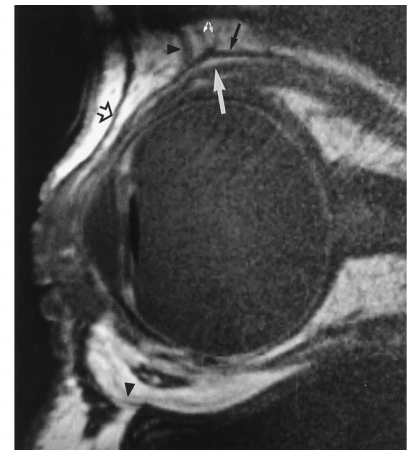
T1-weighted sagittal MR image (600/20/2) of the left orbit of a 56-year-old patient with malignant choroidal melanoma (not shown) and artificial lens. The V-shaped Whitnall's ligament (small white arrows) between orbital roof and levator palpebrae muscle (solid black arrow, levator aponeurosis; large white arrow, Müller's muscle) is clearly depicted. Arrowheads indicate orbitale; open arrow, orbicularis oculi muscle.
